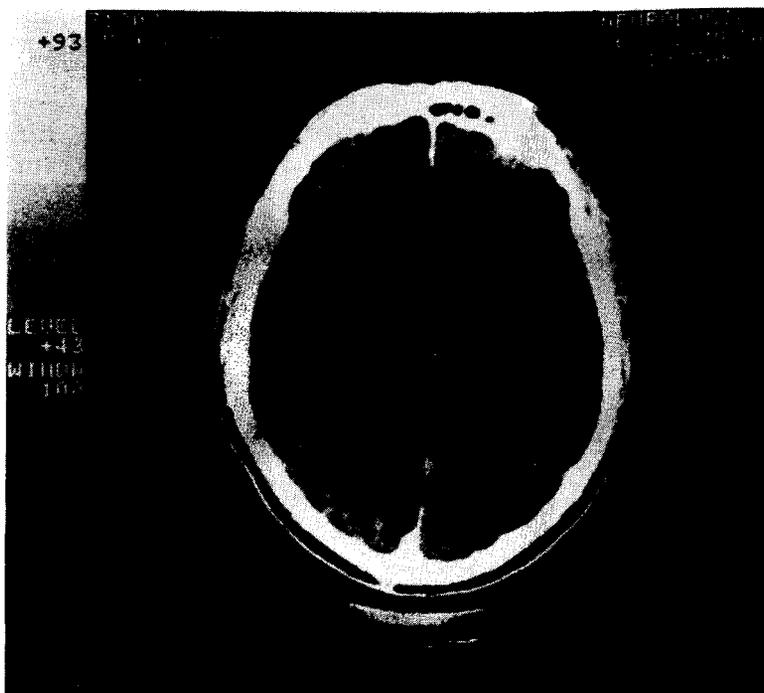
Patient 2: the CT shows an area of decreased density in the right occipital lobe.
